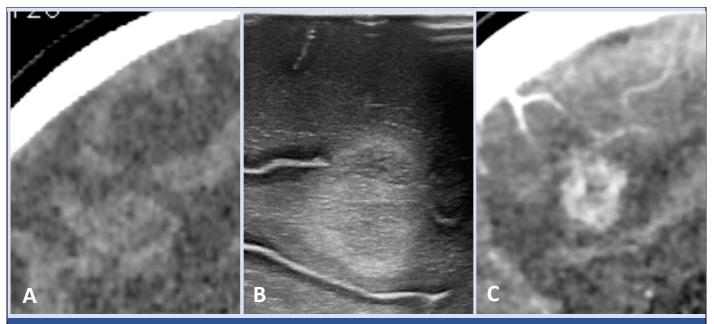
Comparative view of a frontal region metastasis. A. CT without contrast enhancement; B. IoUS; C. CT with contrast enhancement.
